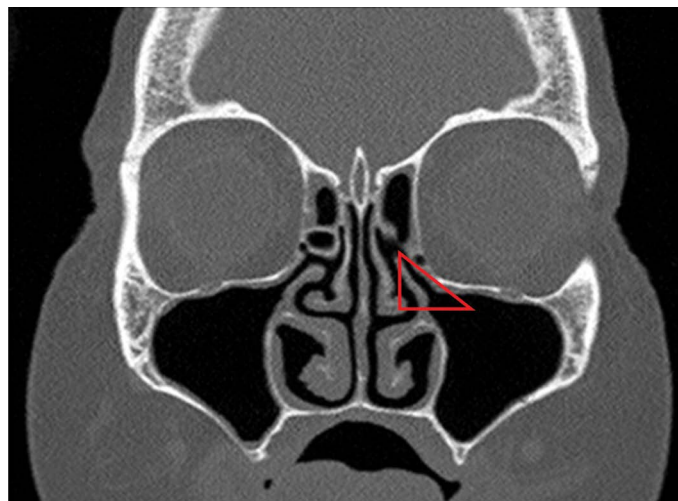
CT scan of paranasal sinuses in frontal projection of patient with normal nasal sinuses and maxillary sinus. The field marked with a triangle corresponds to the unobstructed ostiomeatal complex.
